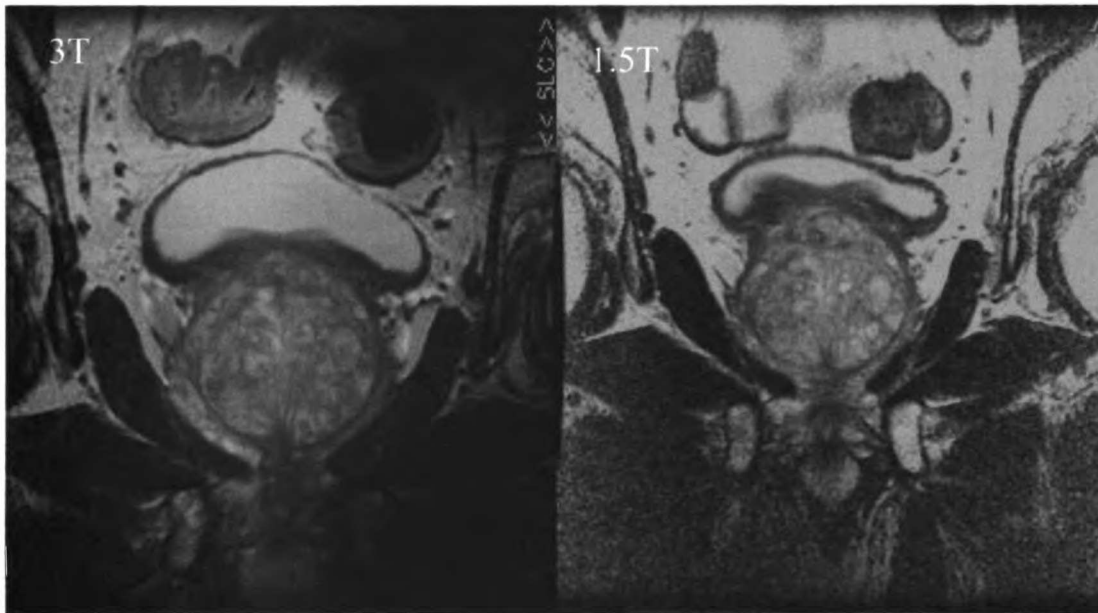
Oblique coronal T2-weighted FSE images acquired at 3T in 3:42 using 256x192 encoding matrix, 6000x/102ms TR/TE, 3mm thick slices and 14 cm FOV (16 cm for 1.5T). Note the SNR increase of the 3T images over the 1.5T images.
